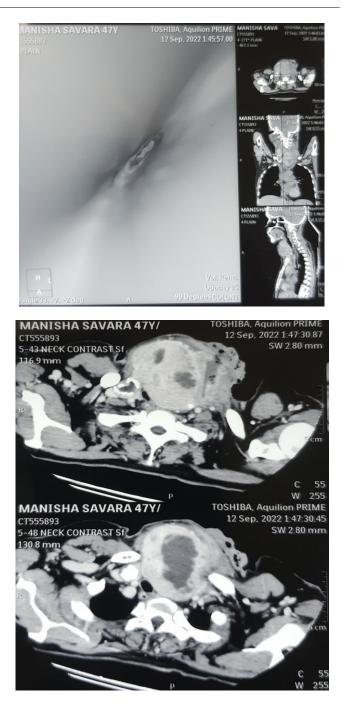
CT Virtual Bronchoscopy showing a) Narrowing of Tracheal lumen due to compression. b) Axial cuts showing homogenous collection within thyroid gland
